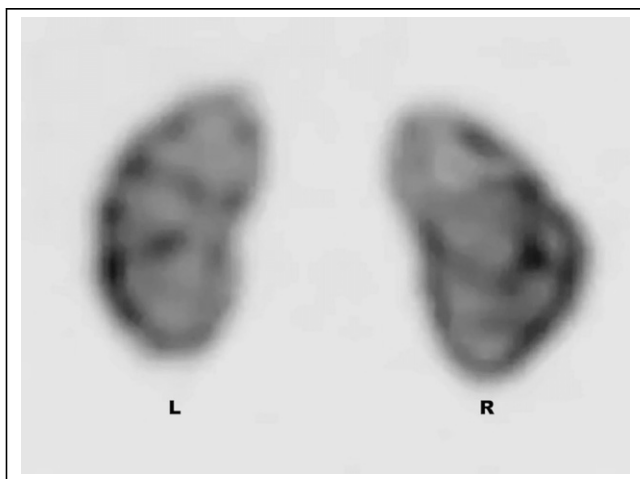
Typical ^{99m}Tc -DMSA renal SPECT. Maximum intensity projection shows distribution of renal cortex.
